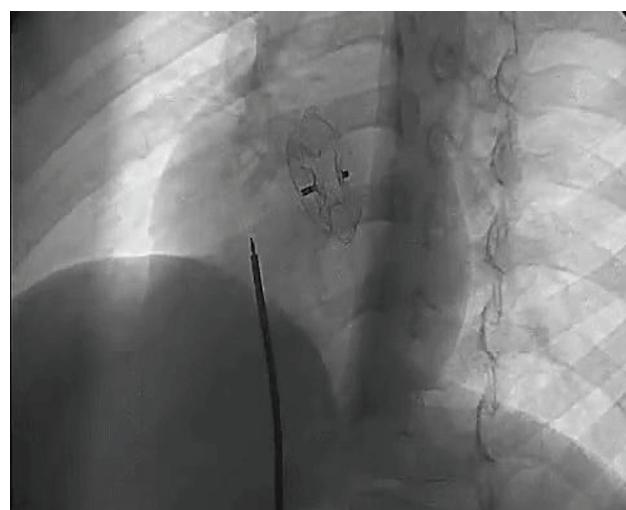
X-ray of atrial septal defect Amplatzer occluder at the end of the procedure.
